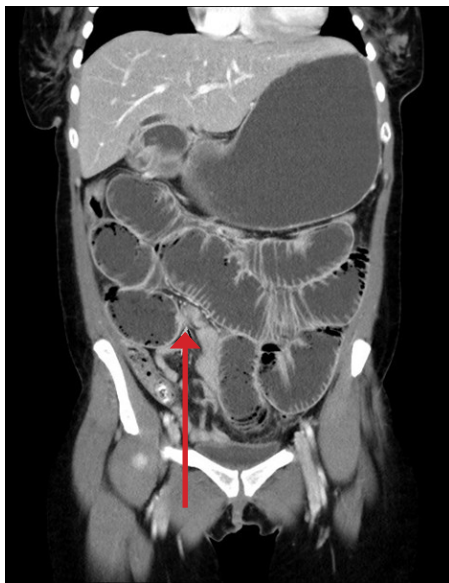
CT scan of the abdomen demonstrating adhesive small bowel obstruction with a point of obstruction in the proximal ileum
